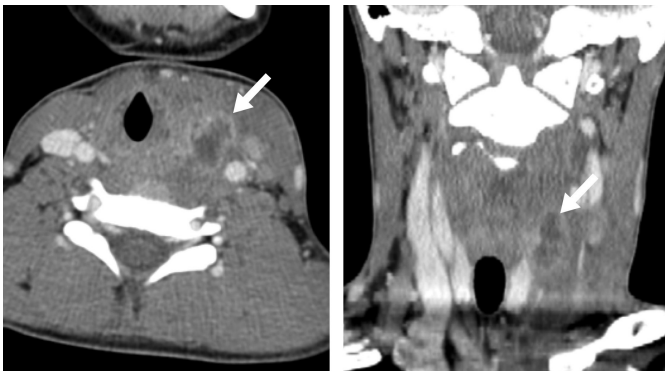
CT scan of neck of 10-year-old patient affected by left neck abscess (arrow) related to pyriform sinus fistula. Often the fistula is not clearly visualized with an ordinary CT scan during an infection of the neck. CT, computed tomography.
